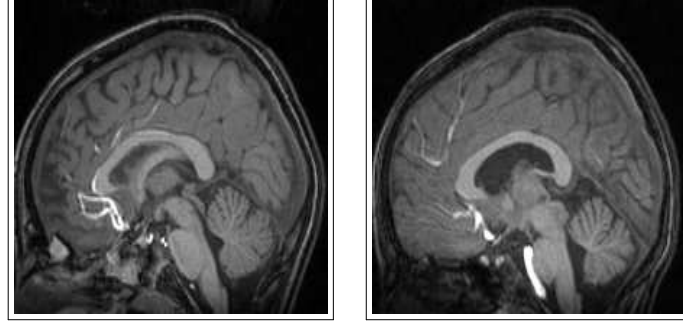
Example of two T1-weighted images with large anatomical differences. There is a topological difference, both in 3D and in the midsagittal section, in the connectivity between the fornix and the corpus callosum. Such differences pose a challenge to whole-brain registration methods.
